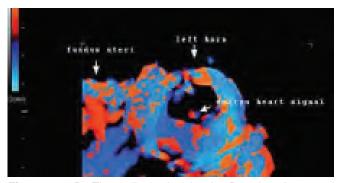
Three-dimensional color Doppler ultrasound of cornual pregnancy. Prominent peritrophoblastic flow indicates vital trophoblast
